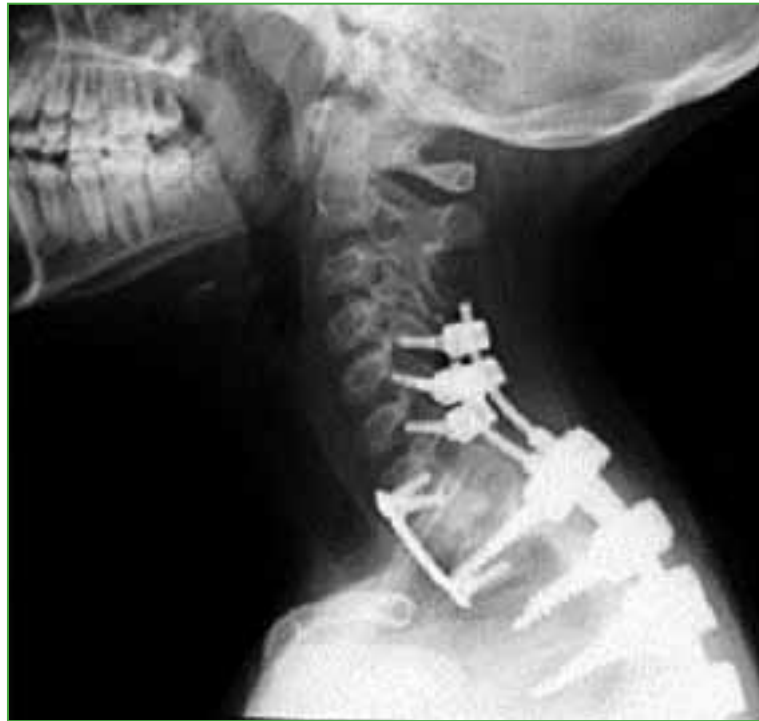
Postoperative lateral radiograph of the cervical and proximal thoracic spine. Posterior and anterior fixation elements from C5 to T5 are visible.
